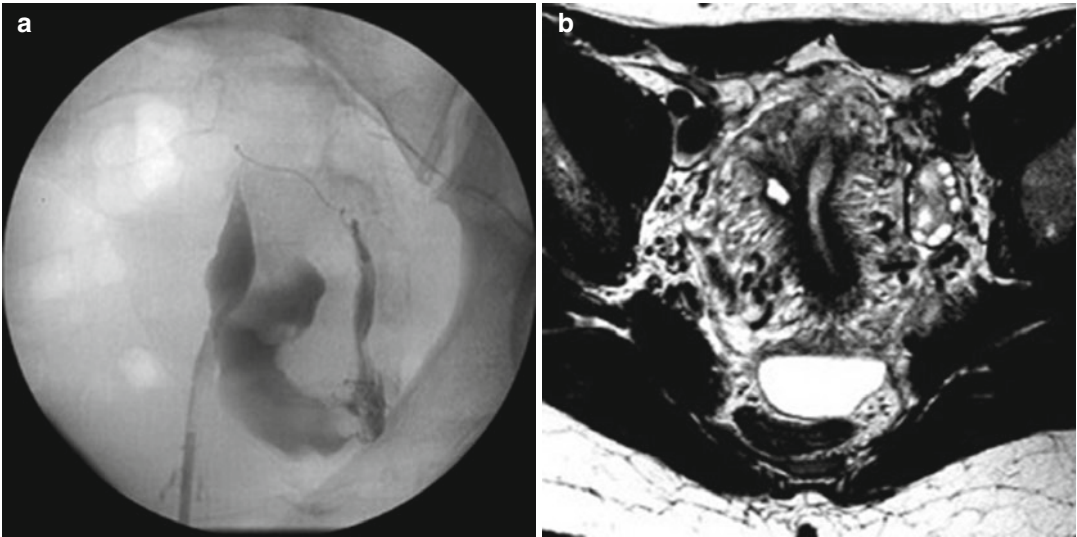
(a, b) Left hemi- uterus with rudimentary horn. The HSG suggested a left hemi uterus; MRI confirmed the presence of a non-communicating functioning right rudimentary horn. U4a C0 V0
